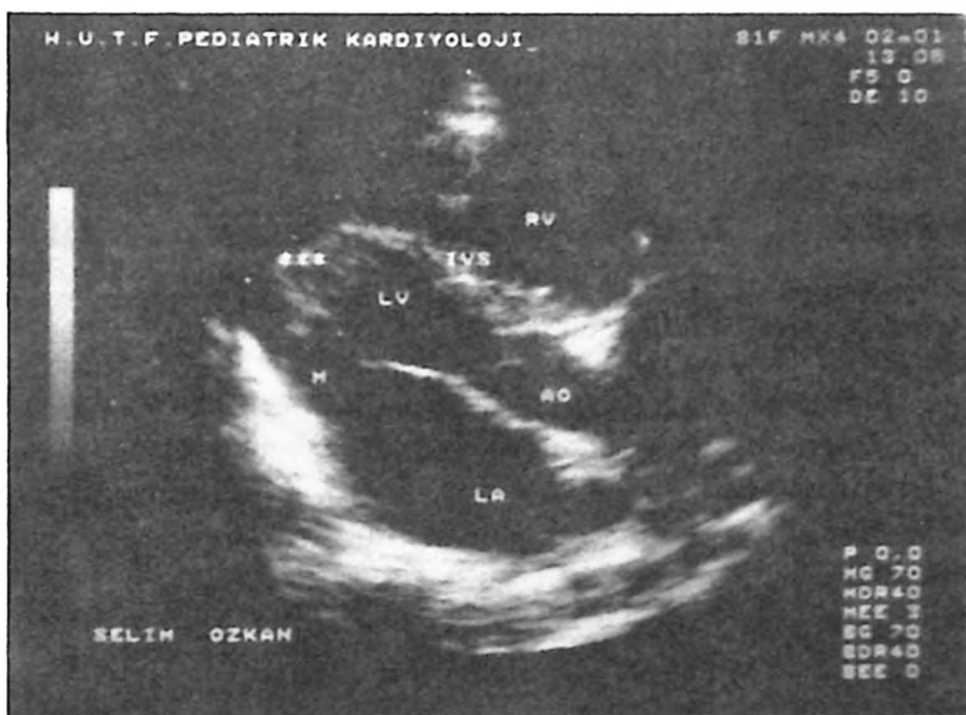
Parasternal long axis view echocardiogram. Obliteration of left ventricular apex is seen (xxx).
